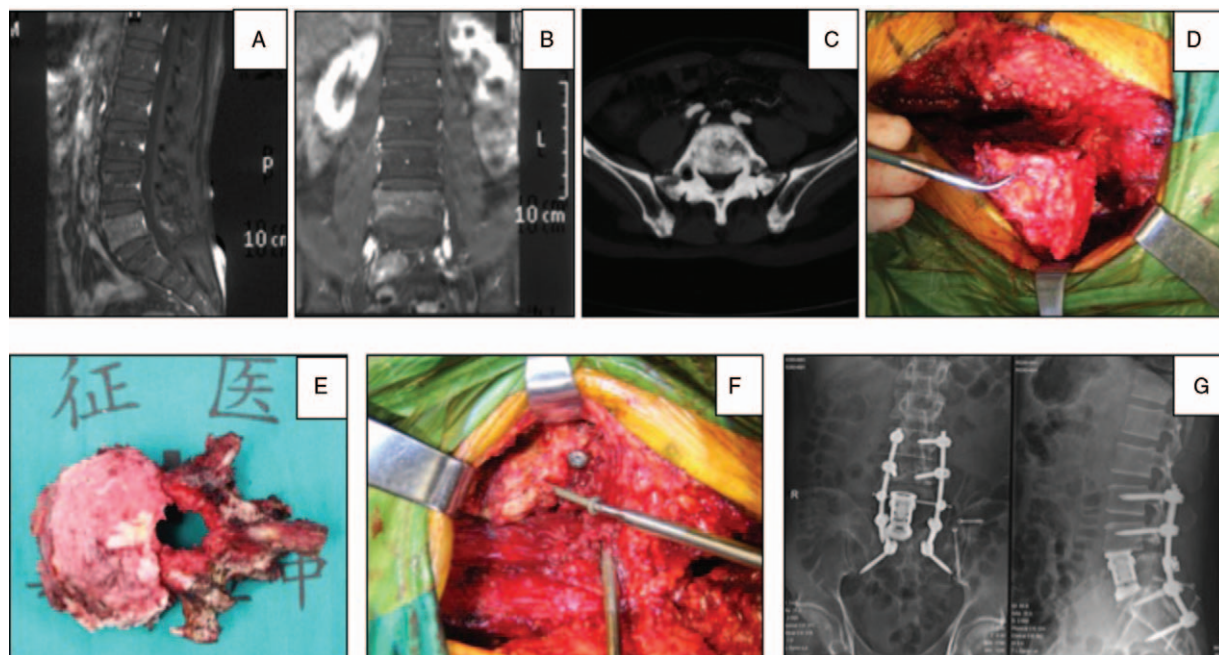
(A–C) Preoperative images revealed a vertebral lesion of the fifth lumbar. (D–F) Intraoperative images include fabrication of the iliac graft, en bloc spondylectomy of L5, and the replacement of the graft. (G) Postoperative x-ray.
